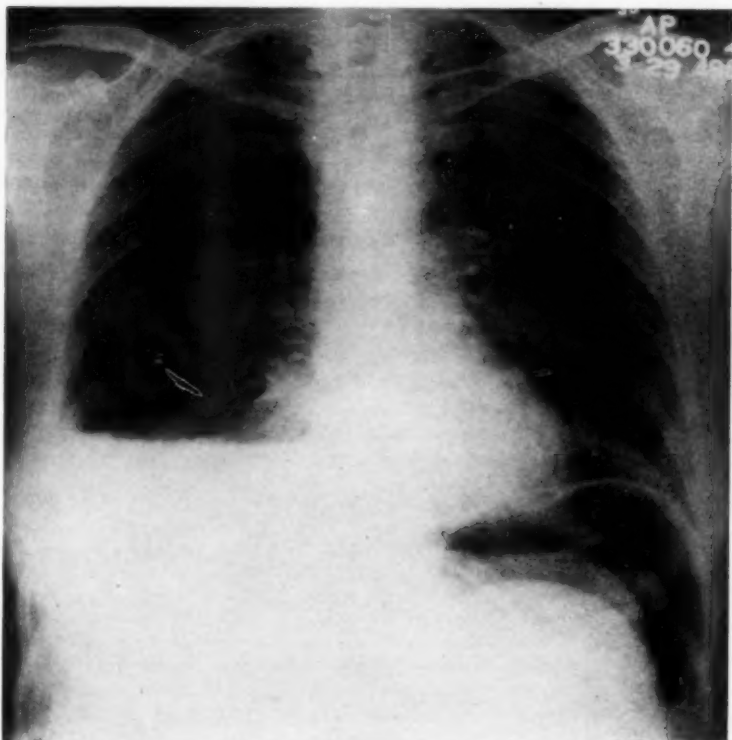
Chest x-ray taken 15 minutes after induction of pneumoperitoneum demonstrating right hydropneumothorax with 25 per cent collapse of the right lung.
